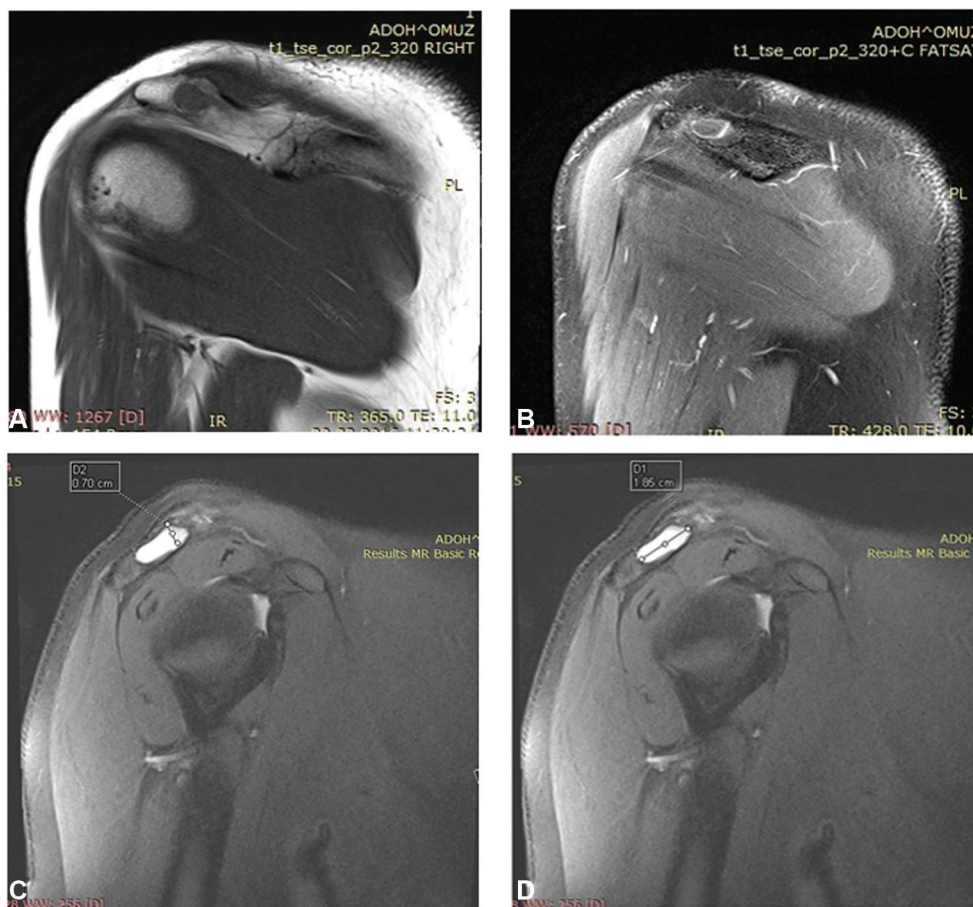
(A) Coronal T1-weighted preoperative magnetic resonance imaging (MRI) scan of the right shoulder showing a well-countered homogenous hypointense lesion with no expansion in the acromion. (B) Coronal postcontrast T1-weighted preoperative MRI with peripheral thin contrast, but absence of the material in the center of the lesion. (C-D) Coronal lipid-suppressed T2-weighted preoperative MRI showing a homogenous hyperintense well-countered lesion with a thin sclerotic wall in the acromion.
